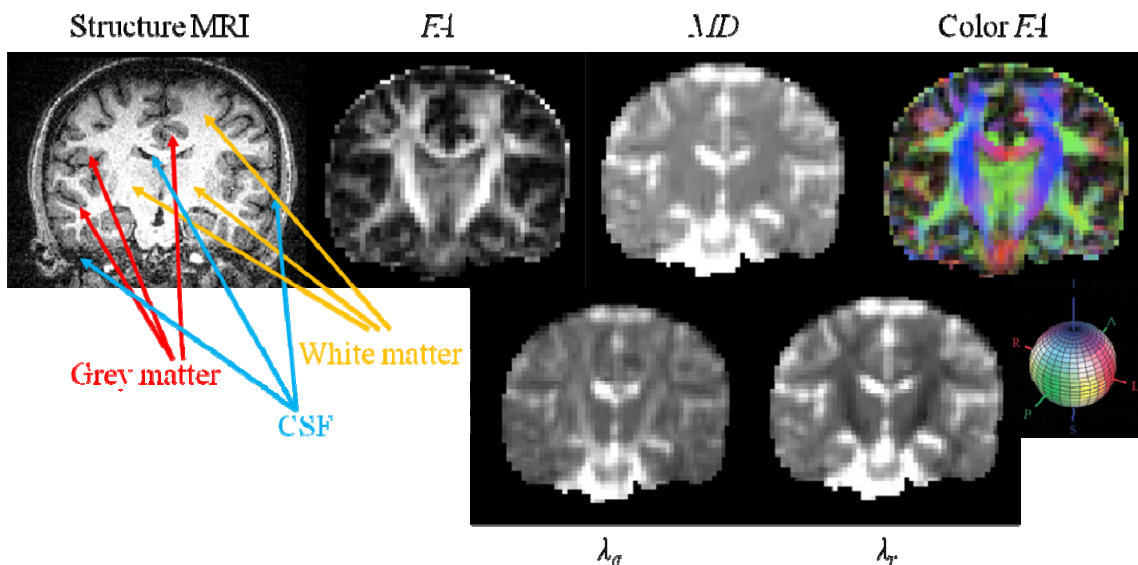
Brain structure MRI image and DTI maps ( $FA$ ,  $MD$ , Color  $FA$ ,  $\lambda_a$  and  $\lambda_r$ ). Indicated in the structure MRI image are grey matter (grey regions as pointed using red arrows), white matter (white regions as pointed using yellow arrows) and CSF (dark regions as pointed using blue arrows). Color  $FA$  shows the principle diffusion direction, color-coded. Blue: Inferior-Superior; Red: Left-Right; Green: Anterior-Posterior.
